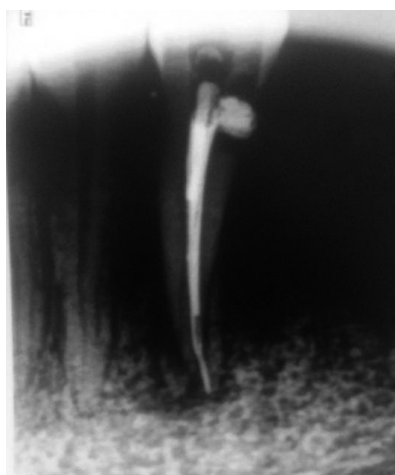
Preoperative radiograph 33
